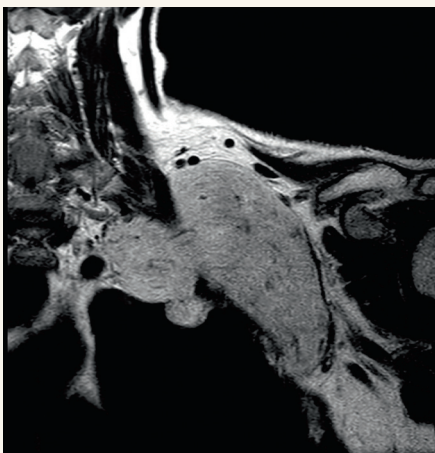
(T1-weighted coronal MRI, demonstrating the dumbbell shape of the hibernoma.
